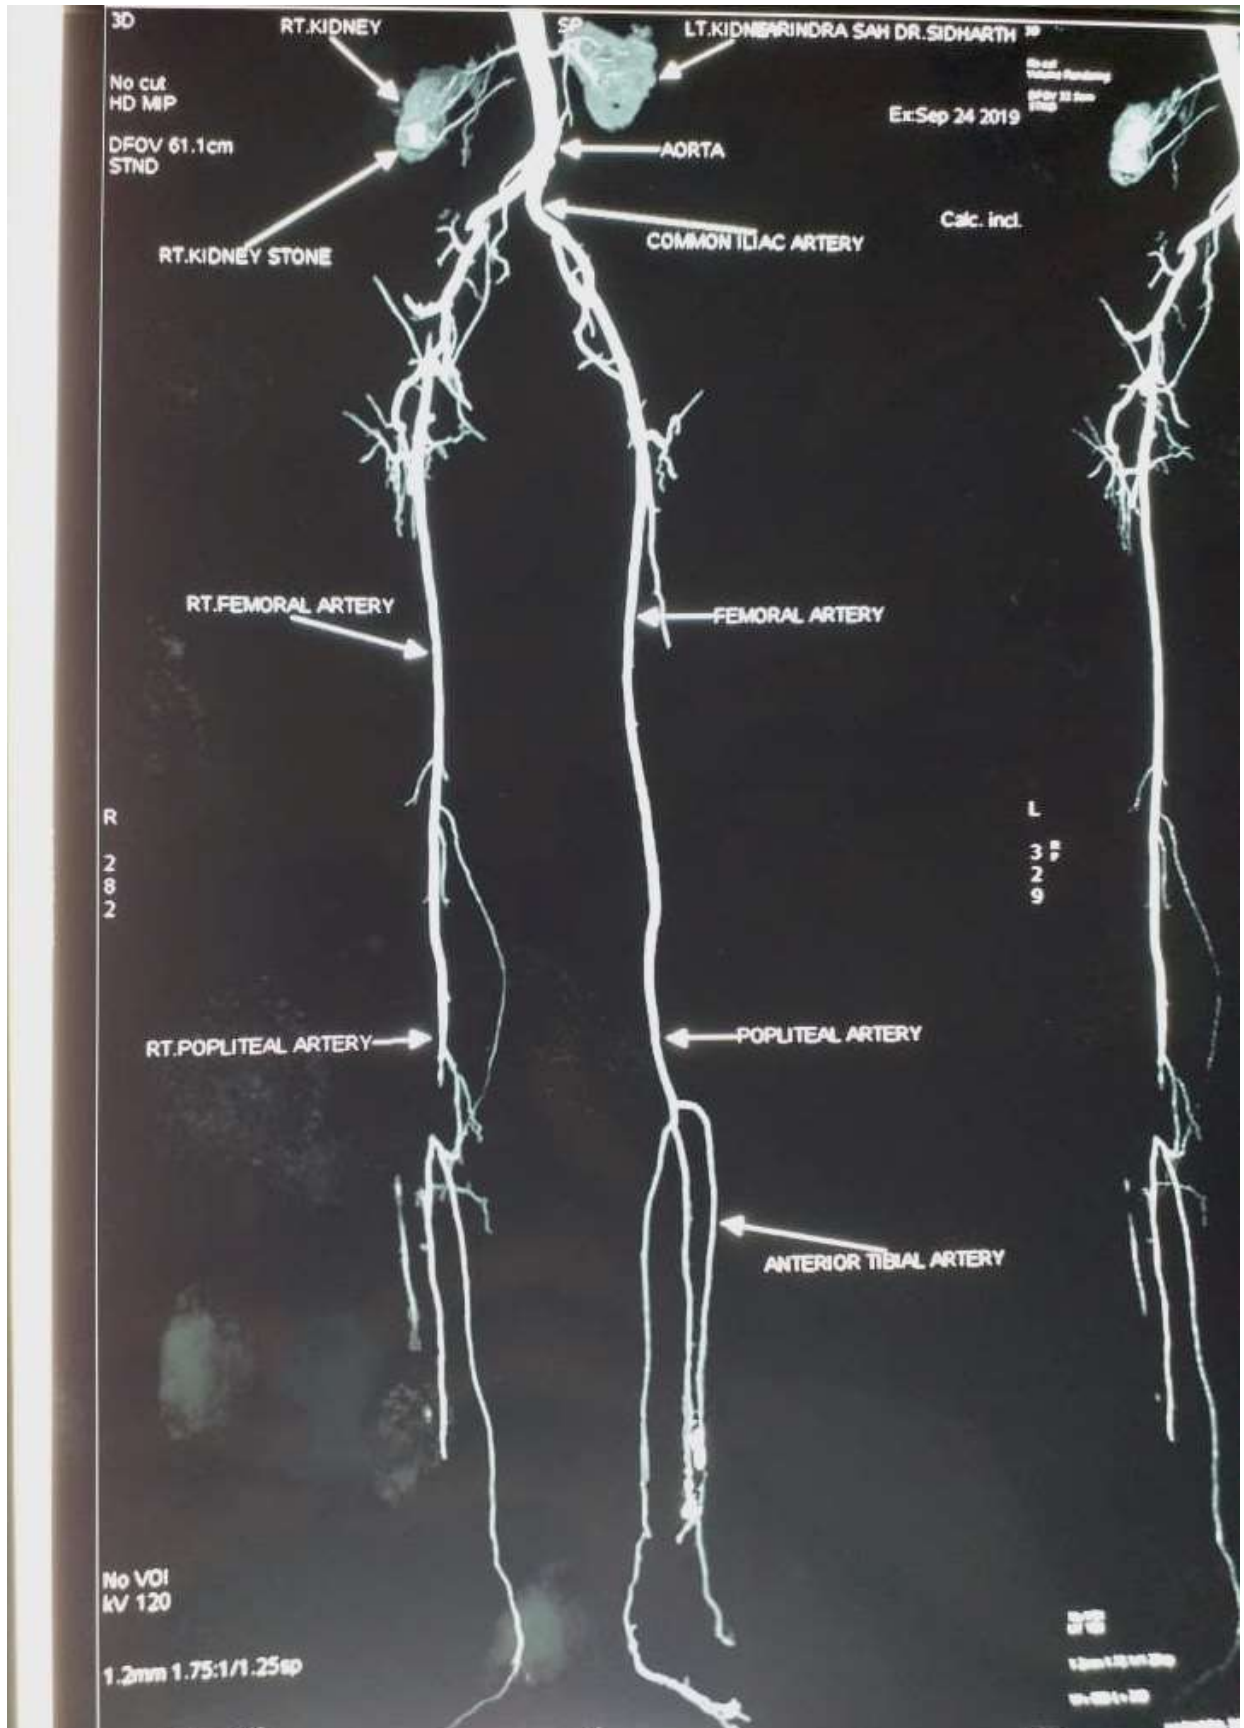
CT angiography of aneurysm arising from right external iliac artery.
